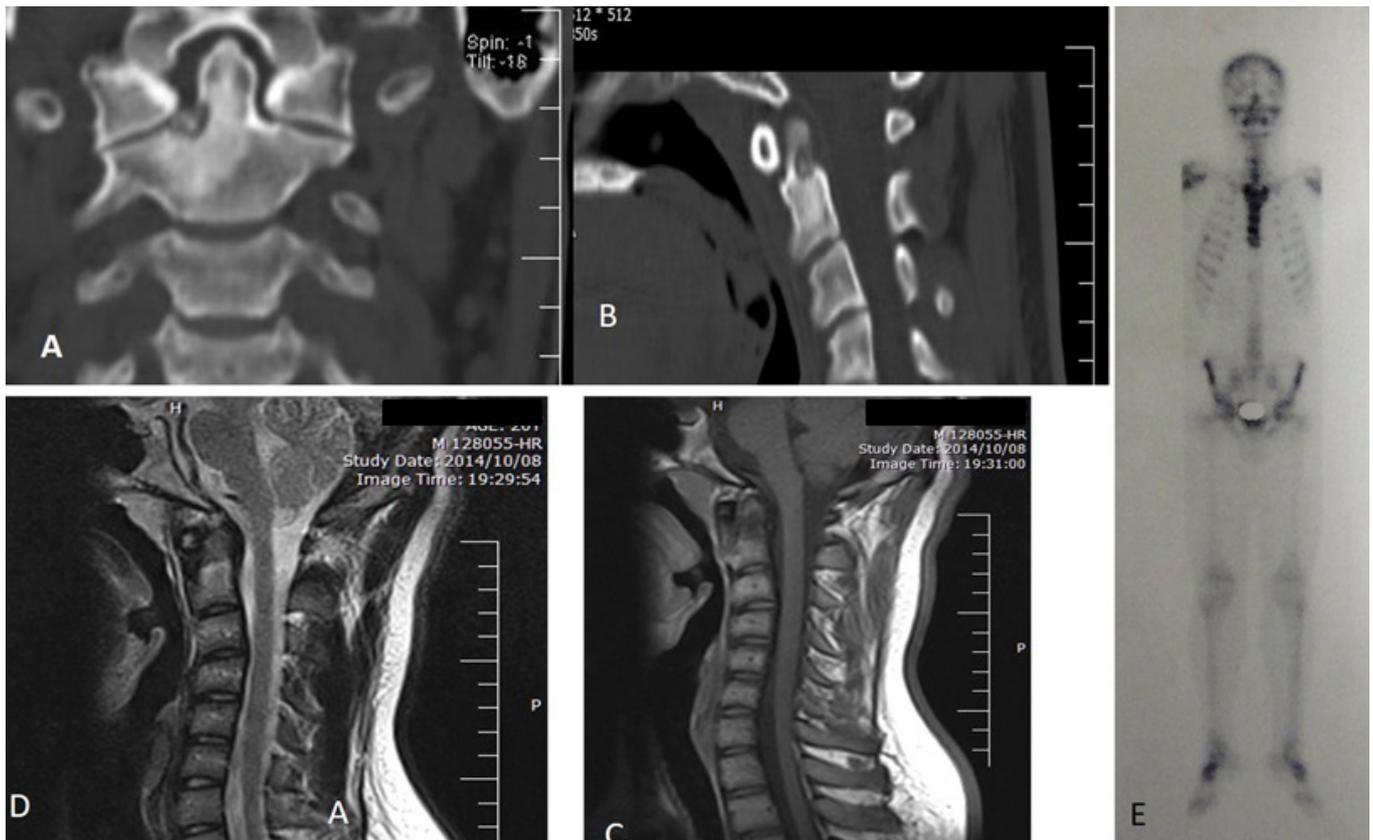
Coronal computed tomography scan of cervical spine showing the presence of the lesion at the odontoid process with central nidus and sclerotic rim.
